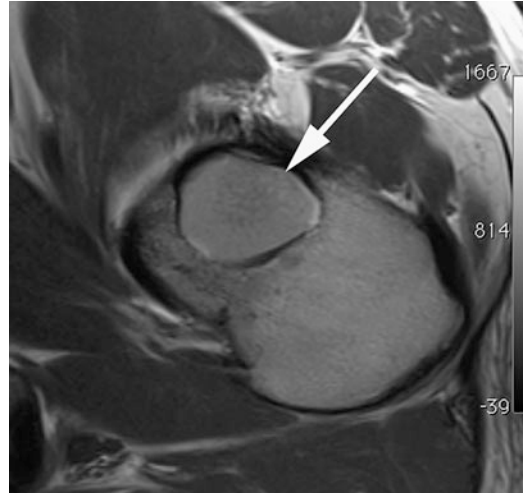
Corresponding T1-weighted transverse image (TR 600 ms, TE 23 ms, slice thickness 4 mm) shows the lesion (*arrow*) with the hypointense sclerotic rim
